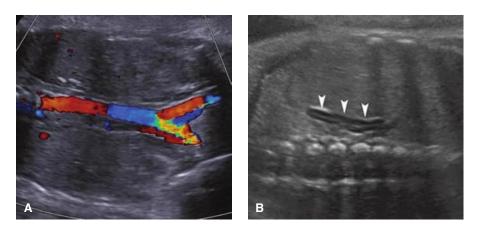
Renal agenesis. A. Coronal image of a fetus with bilateral renal agenesis in which color Doppler of the abdominal aorta is used to demonstrate absence of the renal arteries. B. In this fetus with unilateral renal agenesis, arrowheads point to the adrenal gland (*arrowheads*) filling the renal fossa, which is the "lying-down" adrenal sign.
